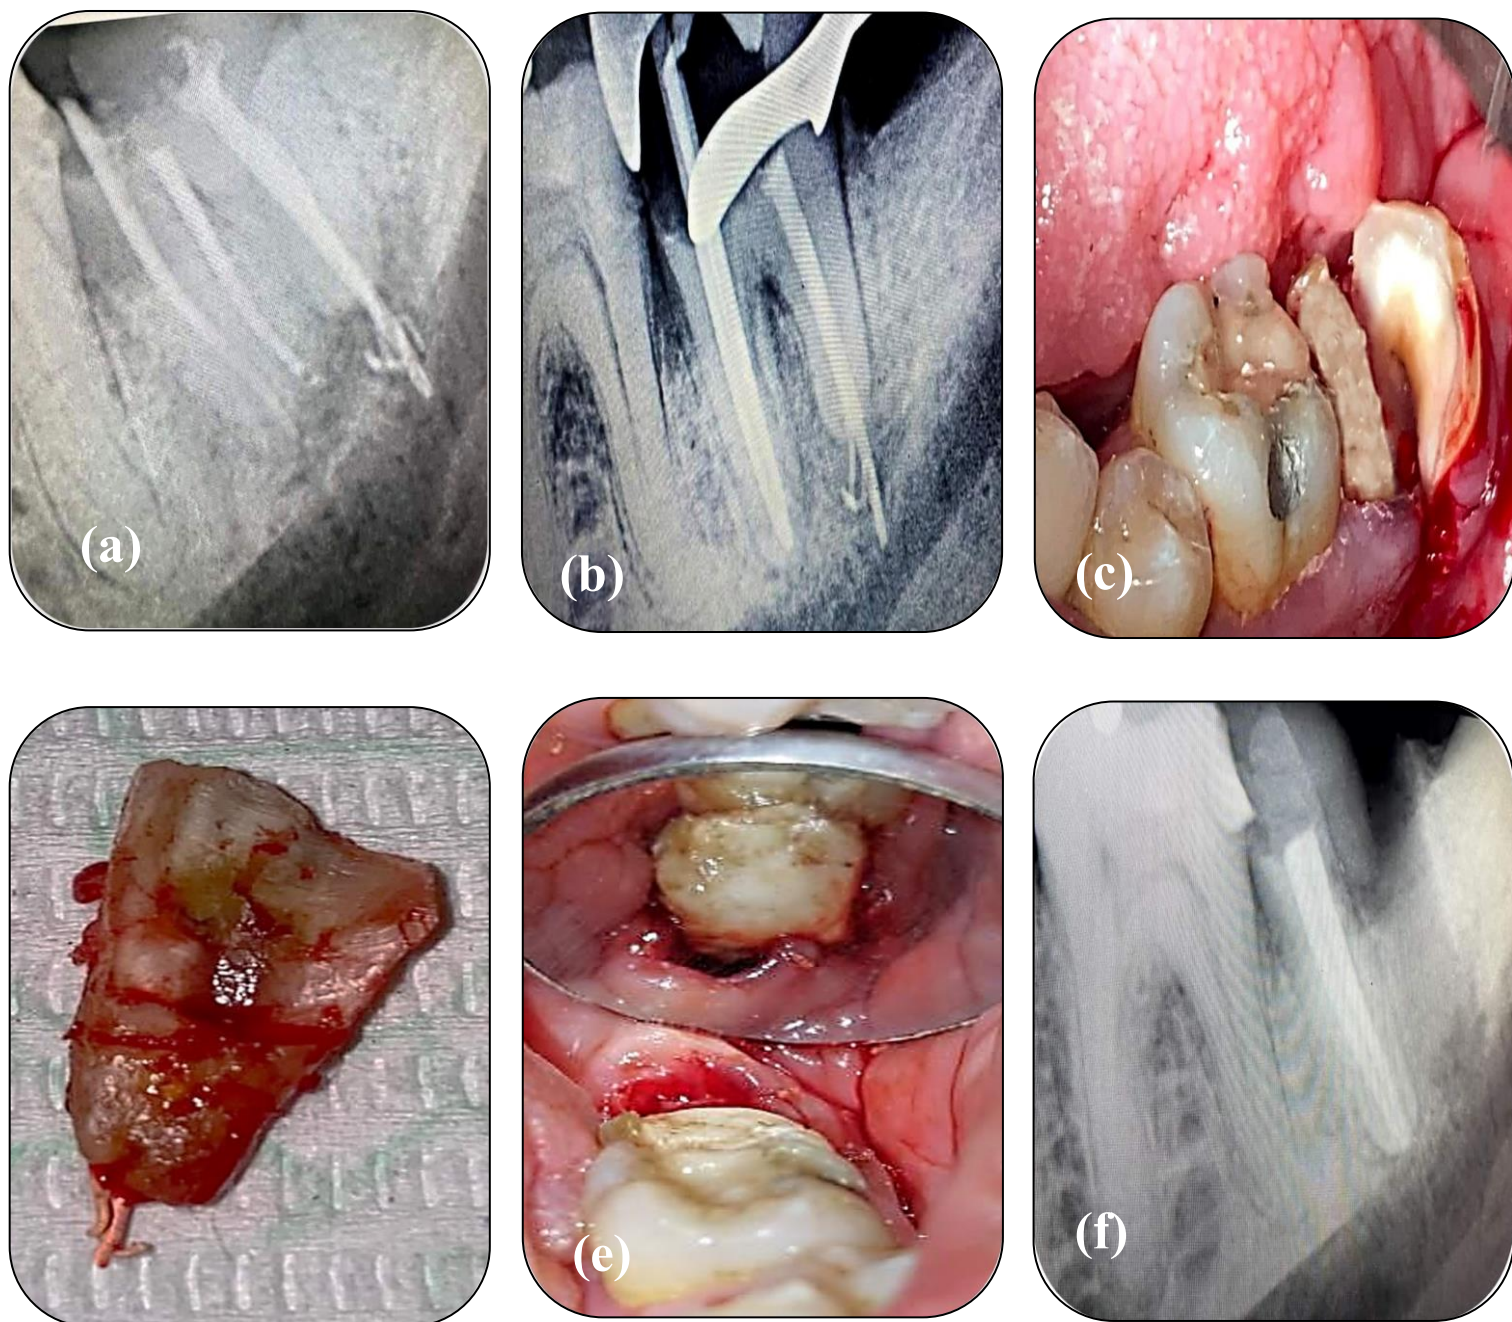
(a) Periapical radiograph showing preoperative status of tooth #37 (b) Radiographic Master cone confirmation (c) Photograph showing the line of resection through the crown. (d) Photograph showing distal root removed with the associated overextended gutta-percha. (e) Surgical field after removal of resected half of tooth structure and (f) Immediate postoperative radiograph.
